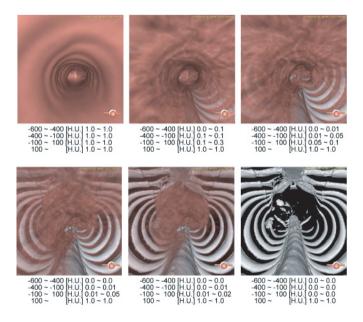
Effect of change in the opacity table (2). H.U. means the Houndsfield Unit used for the density values in CT images. Numerals under the each image show opacity values used in rendering by VolR.
